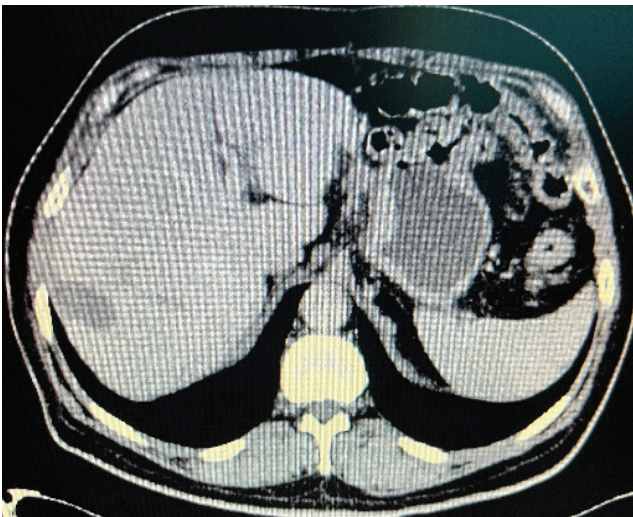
CT scan one month after procedure treatment, there is lesion without contrast in parenchymal contrast phase. Tumor ablated.
